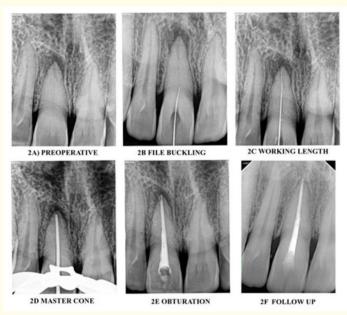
Pre-Operative Radiograph of the Tooth #8 Showing the Obliteration of the Pulp Chamber and the Root Canal and the Radiolucency at the Peri-Apex.
